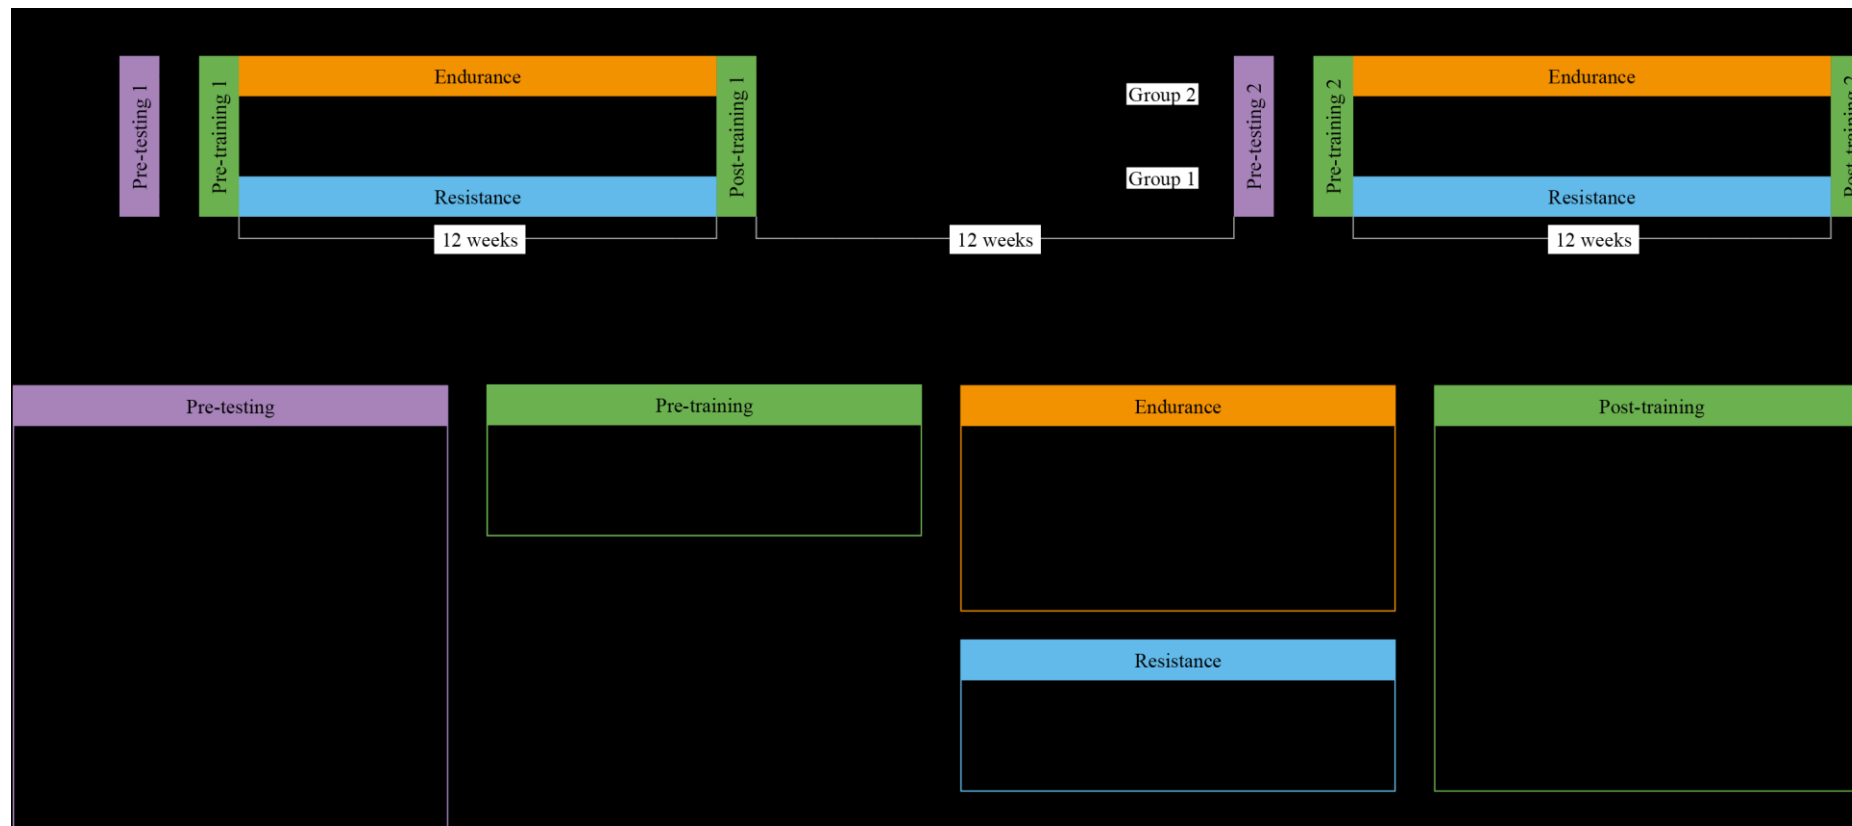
A cross-over training study to investigate the effects of 12 weeks of endurance and 12 weeks of resistance training. DEXA - Dual-energy X-ray absorptiometry, MRI - Magnetic resonance imaging, ADL - Activities of daily living, RM - Repetition maximum, SM&A - Skeletal muscle and subcutaneous adipose tissue biopsy.
